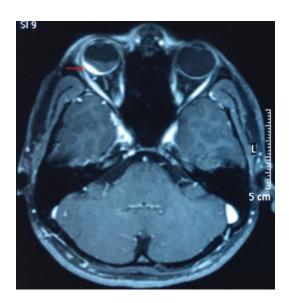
Contrast enhanced MRI of diffuse choroidal detachment showing intense enhancement (arrow)
